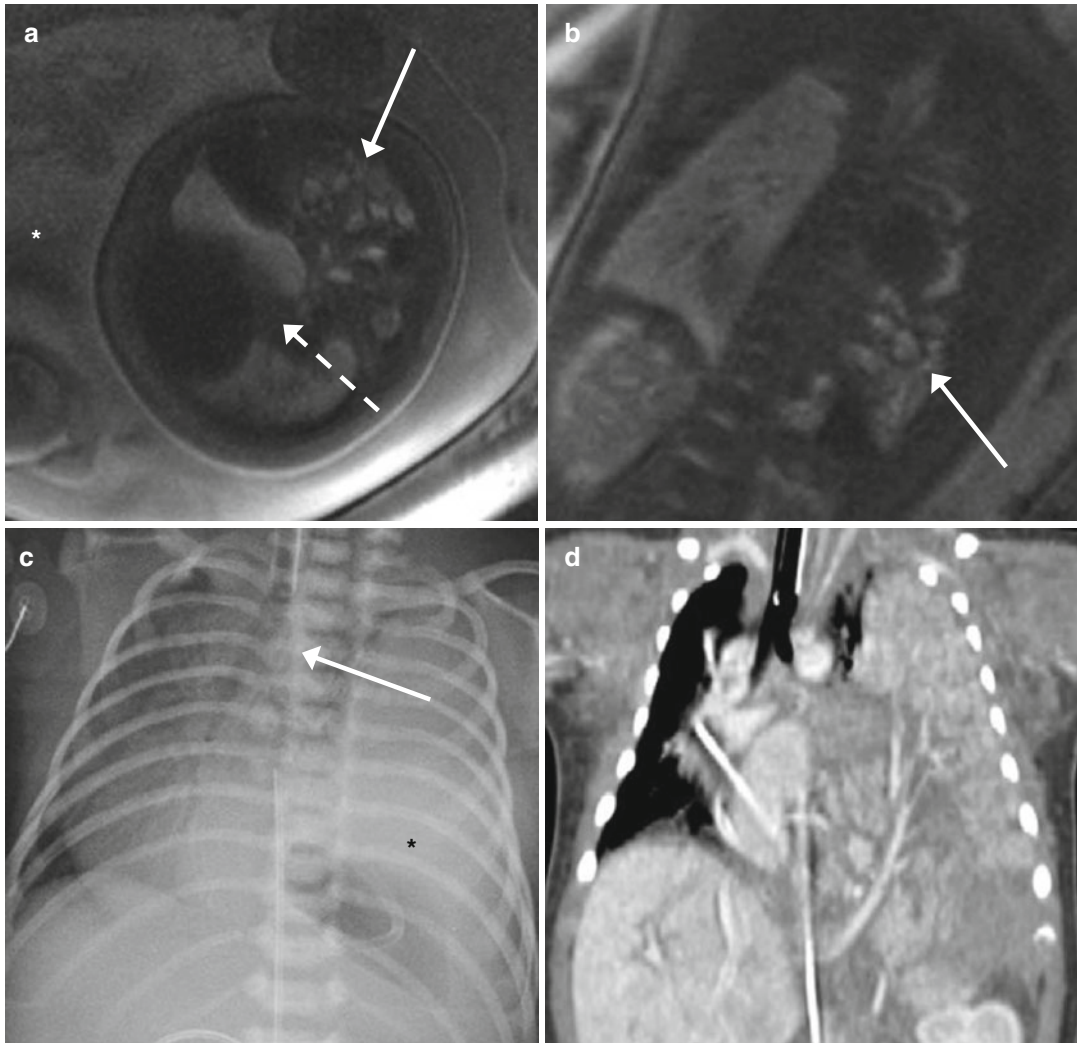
Congenital diaphragmatic hernia (GW 35+3); the lesion was already diagnosed at the ultrasonographic (US) screening of the second trimester. (a, b) Axial (a) and coronal (b) T2-weighted images (TR/TE ∞ /95 ms): bilateral pulmonary hypoplasia secondary to bulky herniation of stomach and intestinal loops in the left chest (*arrows*, a, b), with concomitant contralateral
